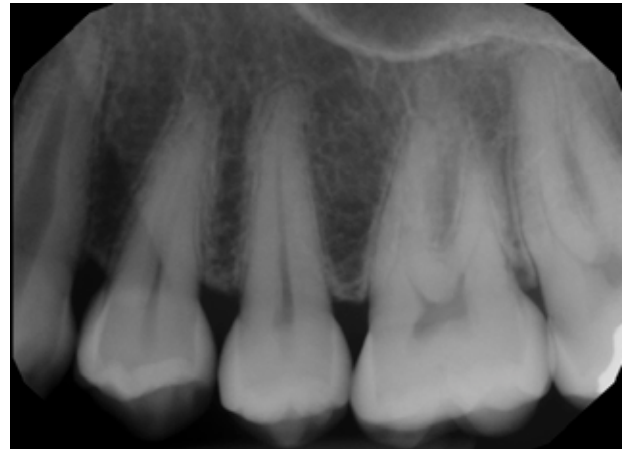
Periapical X ray of the pain area.
